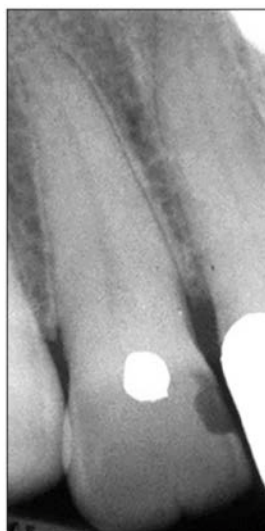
Periapical radiograph of maxillary lateral incisor #7 with coronal cleft.
